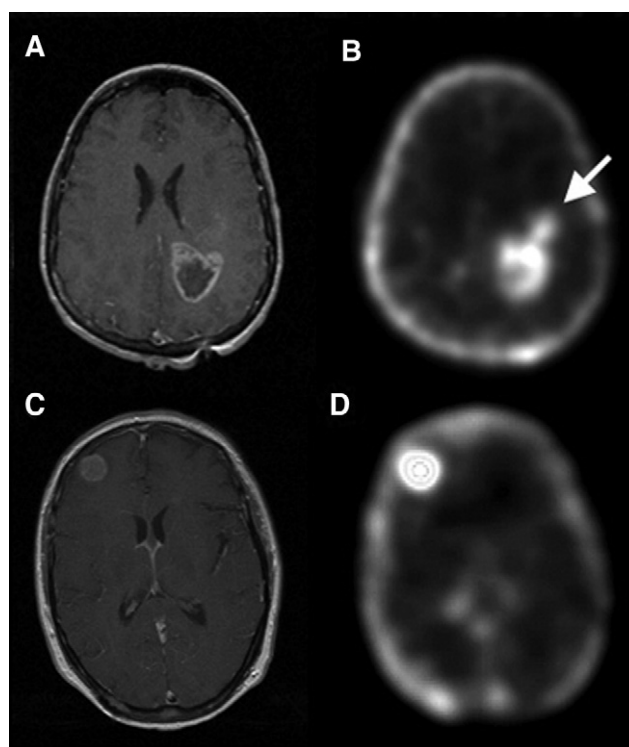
MRI and FCH-PET in primary (A and B) and metastatic (C and D) brain tumors. (A) Glioblastoma multiforme observed as a ring-enhancing lesion in the left occipital lobe on T1-weighted MRI. (B) The corresponding area on PET shows increased FCH uptake. However, abnormal uptake (arrow) was also noted anteriorly beyond the area of enhancement. This characteristic (“peritumoral uptake”) appears specific to high-grade gliomas. (C) Metastatic ovarian carcinoma seen as a ring-enhancing lesion in the right frontal lobe on T1-weighted MRI. (D) In contrast to the previous case, increased FCH uptake on PET corresponds only to the region of contrast enhancement on MRI.
